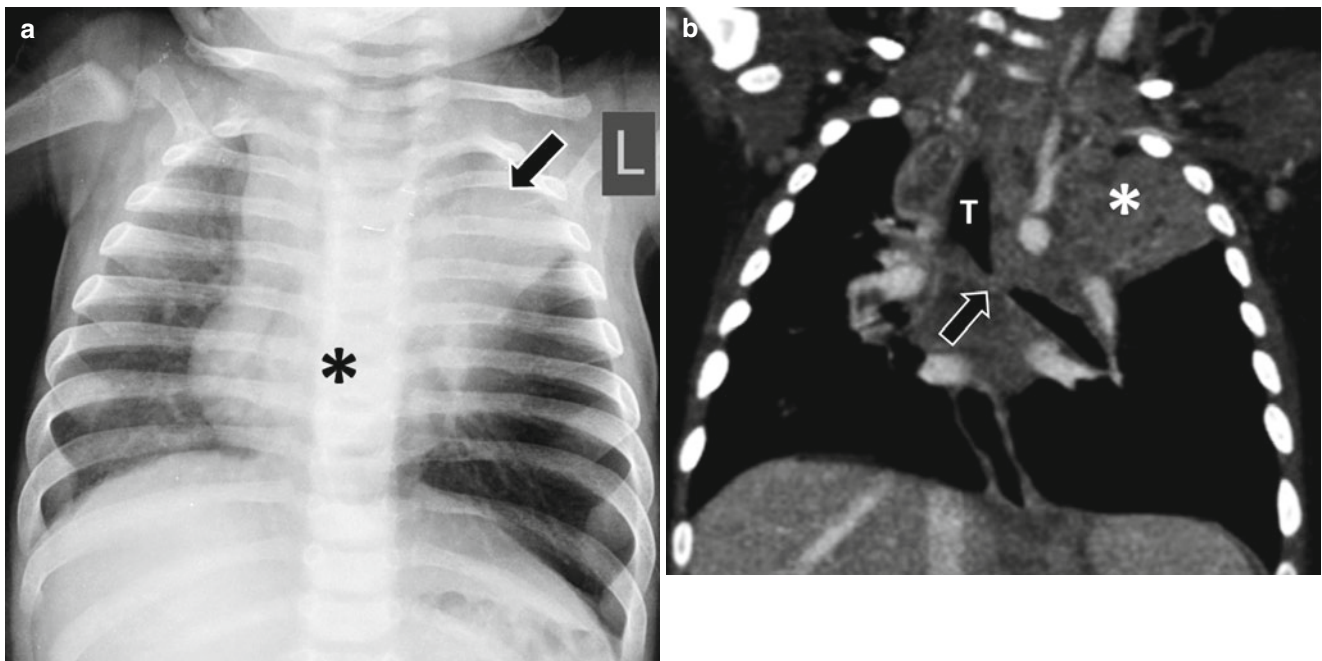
Tuberculosis in a 6-month-old girl with a history of direct contact with active tuberculosis patient who presented with noisy breathing. (a) Frontal radiograph shows an opacity (*asterisk*) in the subcarinal region, likely representing an enlarged lymph node and left
